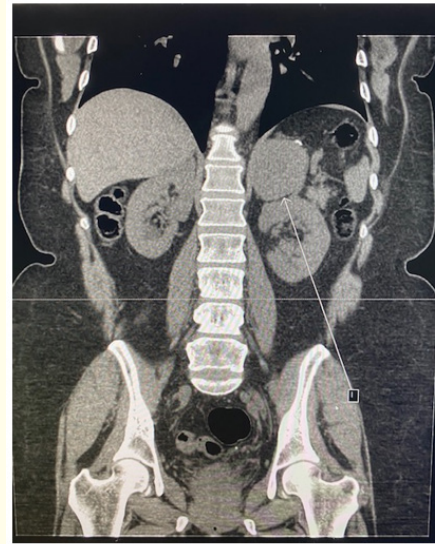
CT scan of abdomen and pelvis without contrast, coronal view revealed 5.5 cm left adrenal mass.
